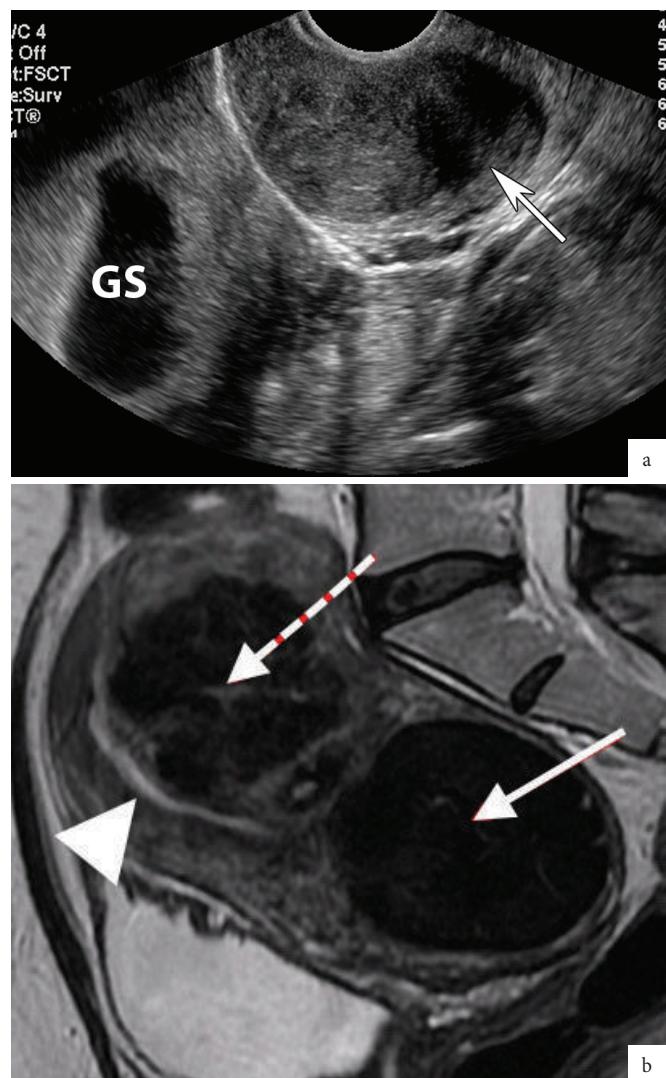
Long axis US scan through the cervix showing a cervical fibroid appearing as a hypoechoic lesion (arrow) in the stromal layer. GS is an intrauterine gestational sac. b. Sagittal T2-weighted MRI scan showing a cervical fibroid (solid arrow) and a posterior body uterine fibroid (dashed arrow), the latter lying posterior to the endometrial cavity (arrowhead).
